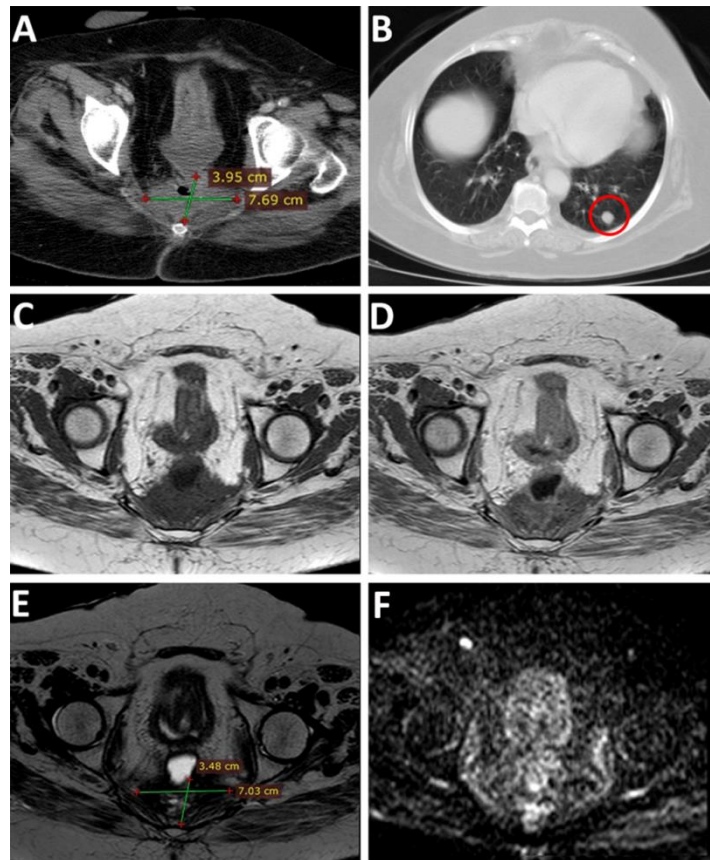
Case (1), (A) axial post contrast CT, (B) axial CT cuts pulmonary window, (C&D) axial T1WI pre and post-contrast MRI, (E) T2WI and (F) DWI.
